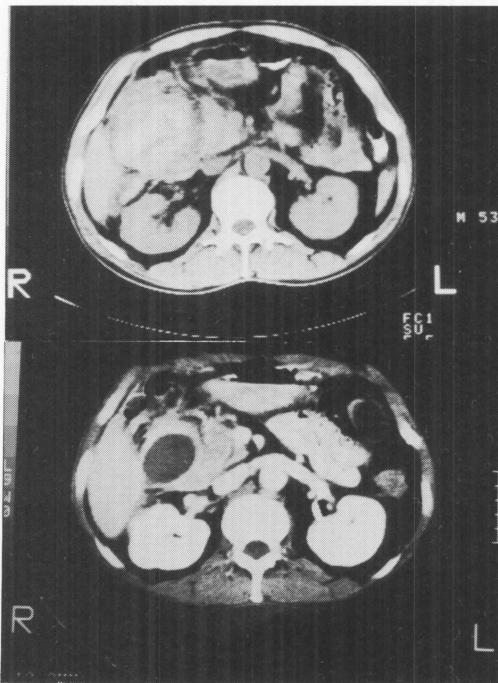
Upper part : CT immediately after hospitalization
